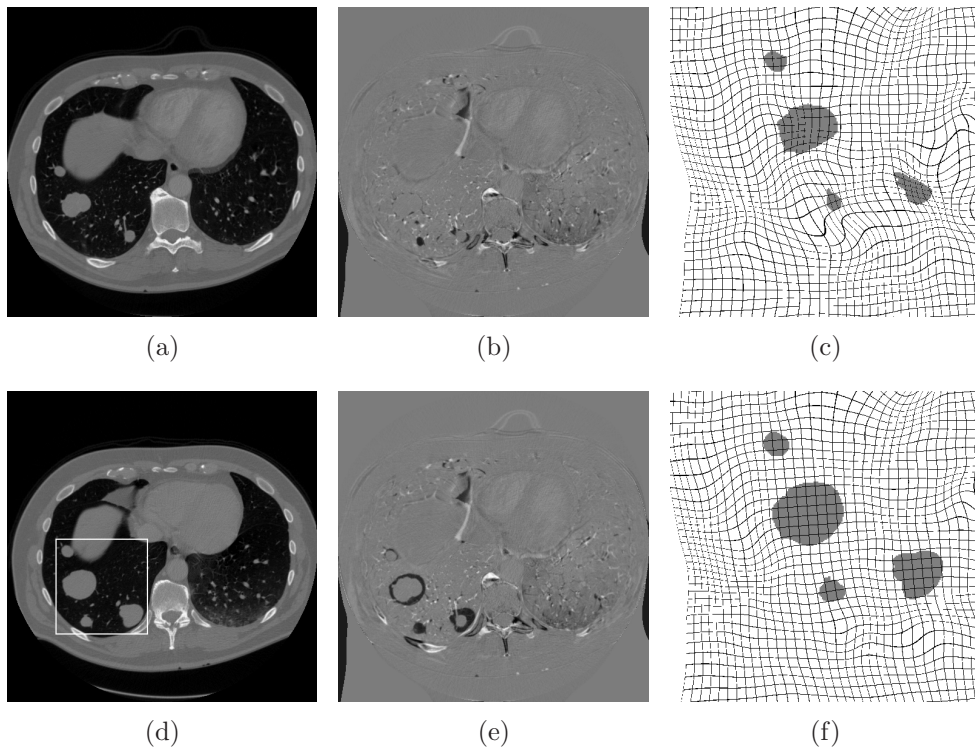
Comparison of NRU and NRP for a slice taken from 3D CT thorax images. The tumours, located within the box (see (d)), are to be kept rigid. (a) and (d): CT slice at time  $t_0$  (the fixed image) and time  $t_1$  (the moving image), respectively; (b) and (e): difference of the registration result with the fixed image, for NRU and NRP, respectively; (c) and (f): the resulting deformation field near the tumours for NRU and NRP, respectively.
